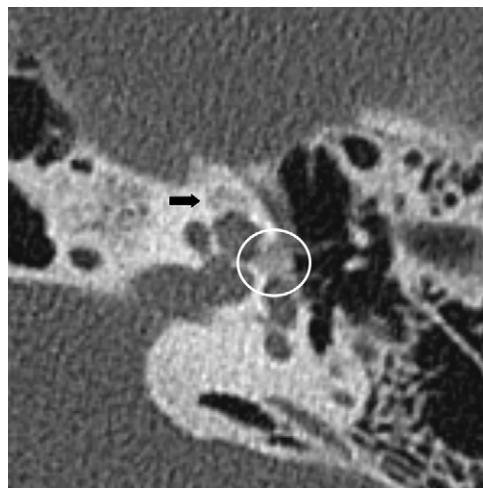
Fenestral and retrofenestral otosclerosis in a 35-year-old patient with a family history of otosclerosis who presented with progressive left-sided conductive hearing loss and pulsatile tinnitus. Axial CT image of the temporal bone shows lucency of the otic capsule adjacent to the oval window and stapes footplate in the region of the fissula ante fenestram (circle) and lucency around the cochlea remote from the stapes footplate (arrow), consistent with fenestral and retrofenestral otosclerosis.
